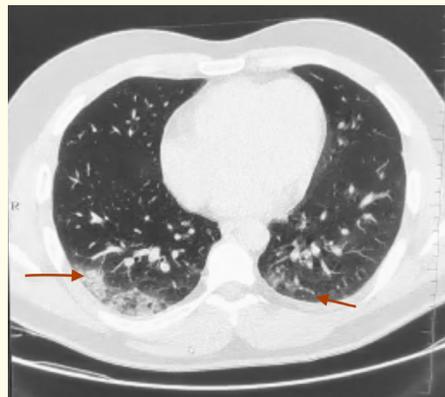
High resolution computed tomography thorax showing B/L lower zone sub-pleural based ground glass opacities.
